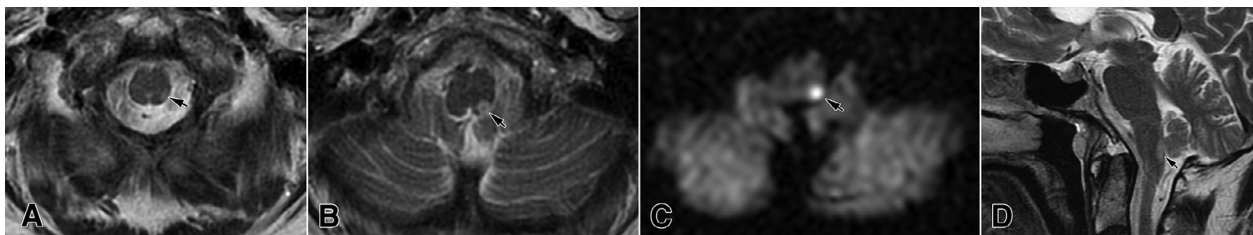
A left dorsal lateral infarction (arrows) of the lower and middle medulla in the axial T2-weighted (A and B) and DWI (C) images, as well as in the sagittal T2-weighted section (D).
